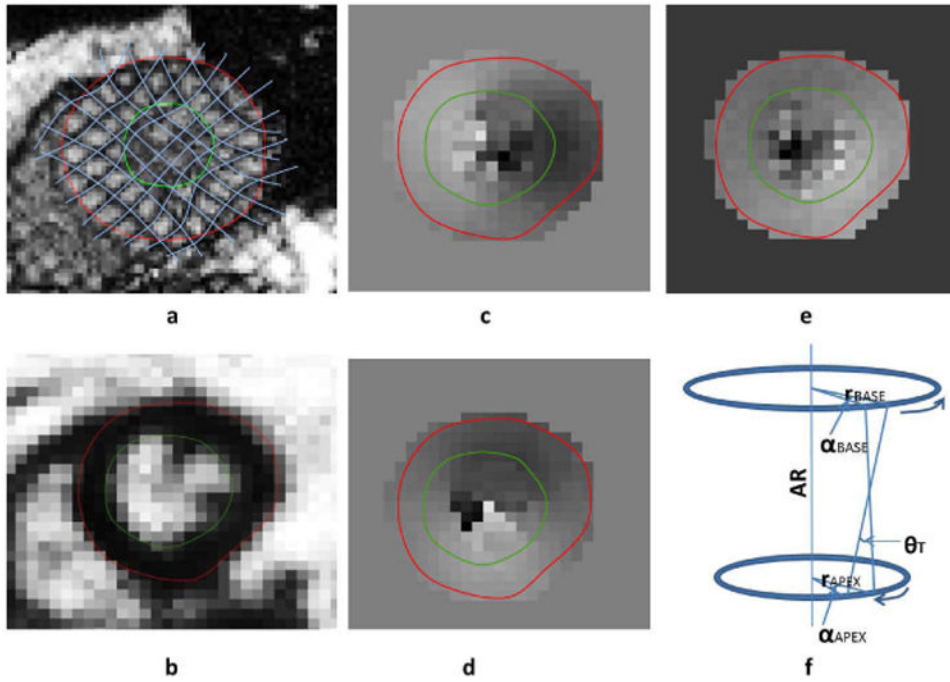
(a) Uninterpolated deformed tag lines in tagged MRI using a semiautomated tag-finding algorithm (b) Flood-filled quality image that guide displacement finding in DENSE. Unwrapped (smooth) phases within the myocardium in (c) vertical, (d) horizontal and (e) longitudinal orientations. (f) Directions of normal rotation (α) at the base and apex and torsion (θ). AR: axis of rotation, r: radius.
